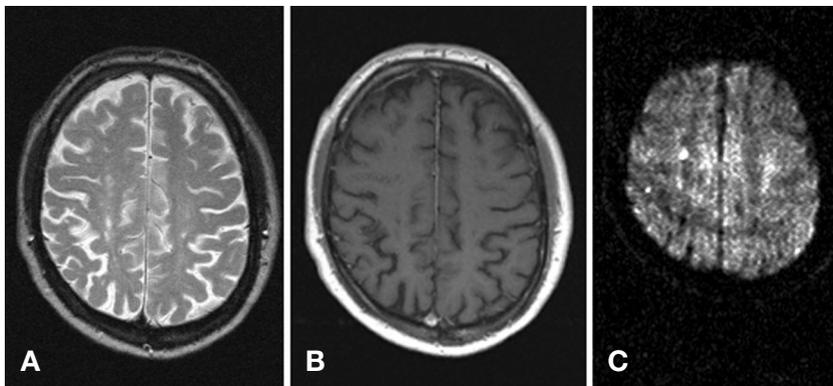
A–C. Diffusion imaging. A T2-weighted spin echo; B contrast-enhanced T1-weighted spin echo; and C diffusion-weighted echo-planar images of a patient with clinical history of repetitive cerebral infarcts. The most recent 48-h-old infarct within the right hemisphere is visible only in the diffusion-weighted echo-planar image (C) with a b-value of 1000 (white spot)
